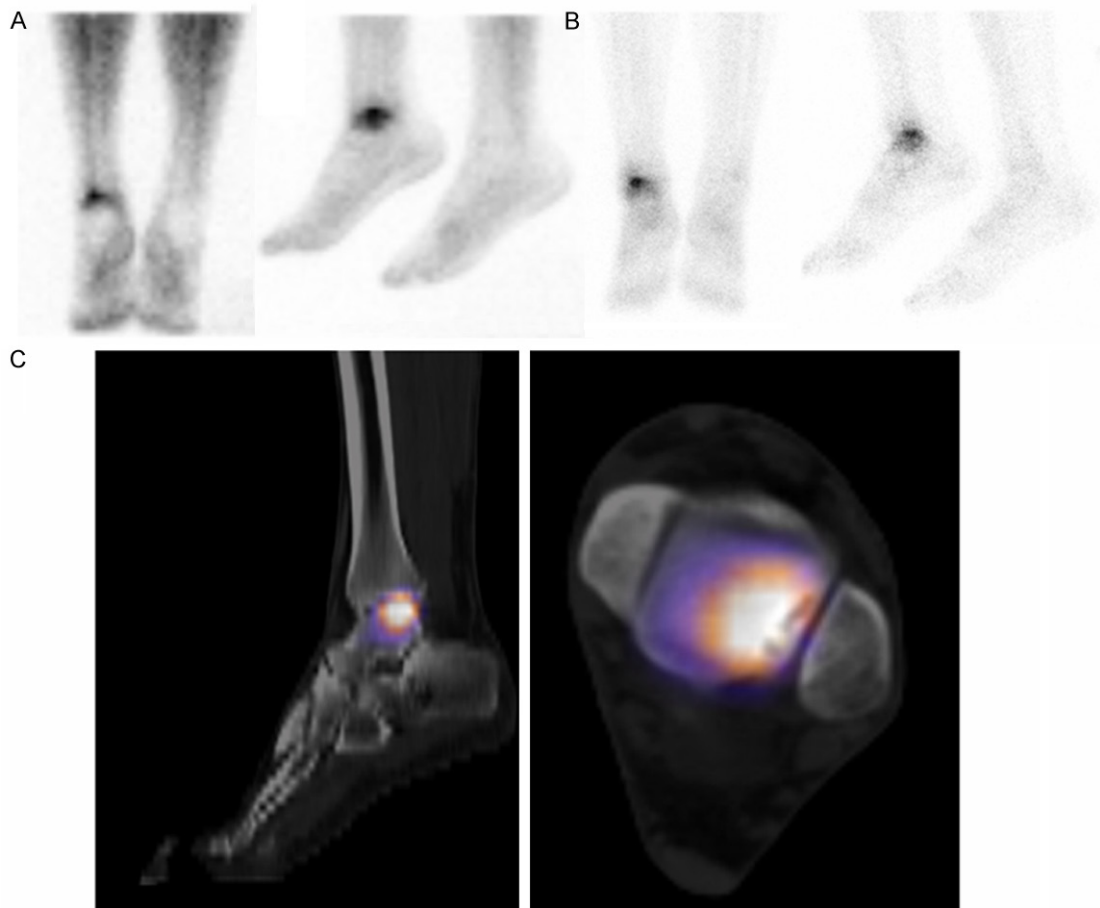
Posterior and lateral blood pool images (A) demonstrate hyperemia in the left ankle joint area. Delayed posterior and lateral (B) images show a similar distribution of activity. Sagittal and axial SPECT-CT images (C) localize the area of uptake in the subarticular region and talar dome, consistent with talar osteochondral lesion.
